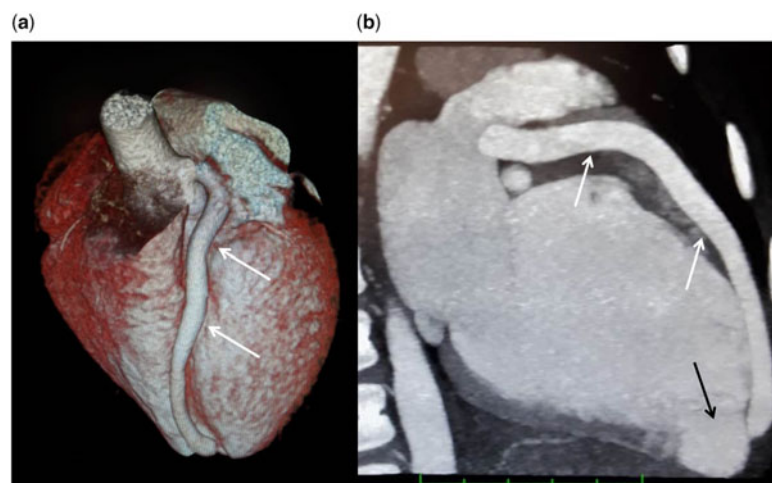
(a and b) Coronary computed tomography showed a significant dilation of the left anterior descending artery (white arrows) and a large fistula from the end of the coronary artery emptying into the apical region of the right ventricular chamber with a diverticular dilation (black arrow).
